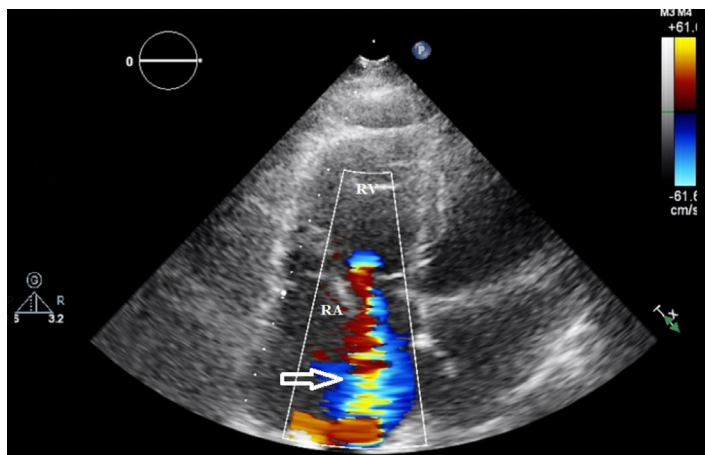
Transthoracic echocardiography shows right atrial (RA) and right ventricular (RV) enlargement, thrombi-in-transit from the RA to the RV
